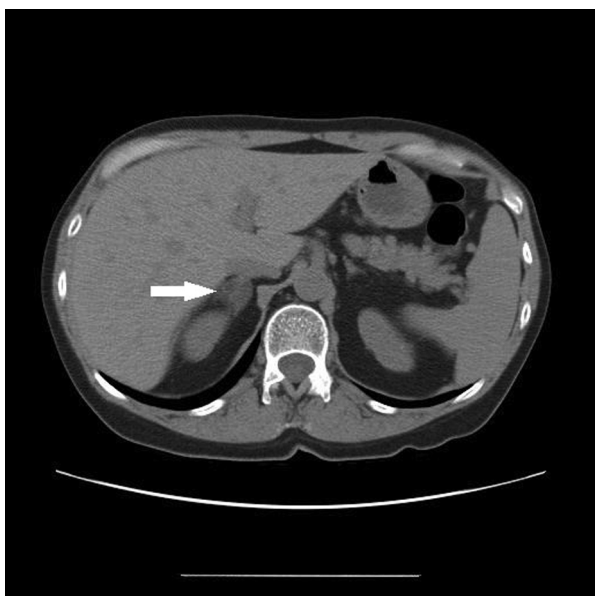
Follow up CT showing a decrease in the size of adrenal adenoma of 1.8 cm (arrow).
